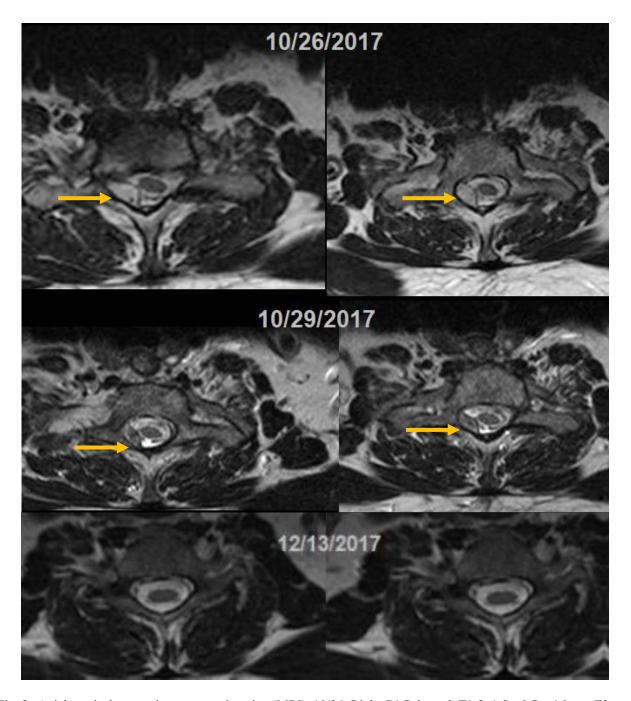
Axial cervical magnetic resonance imaging (MRI). 10/26: Right C6-7 through T1-2, 1.5 x 0.7 x 4.0 cm, T2 hyper-intense with signal intensity similar to CSF, epidural fluid collection causing leftward deviation of the cord and mild deformation, with severe stenosis of the right neural foramina at C7-T1 and T1-T2. 10/29: Slight decrease in size of the right epidural collection, producing similar degree of mild spinal canal narrowing and associated severe neural foraminal narrowing. The collection is T2 hypo-intense to the CSF and spinal cord suggesting early blood products. 12/13: Interval resolution of right posterolateral epidural collection.
